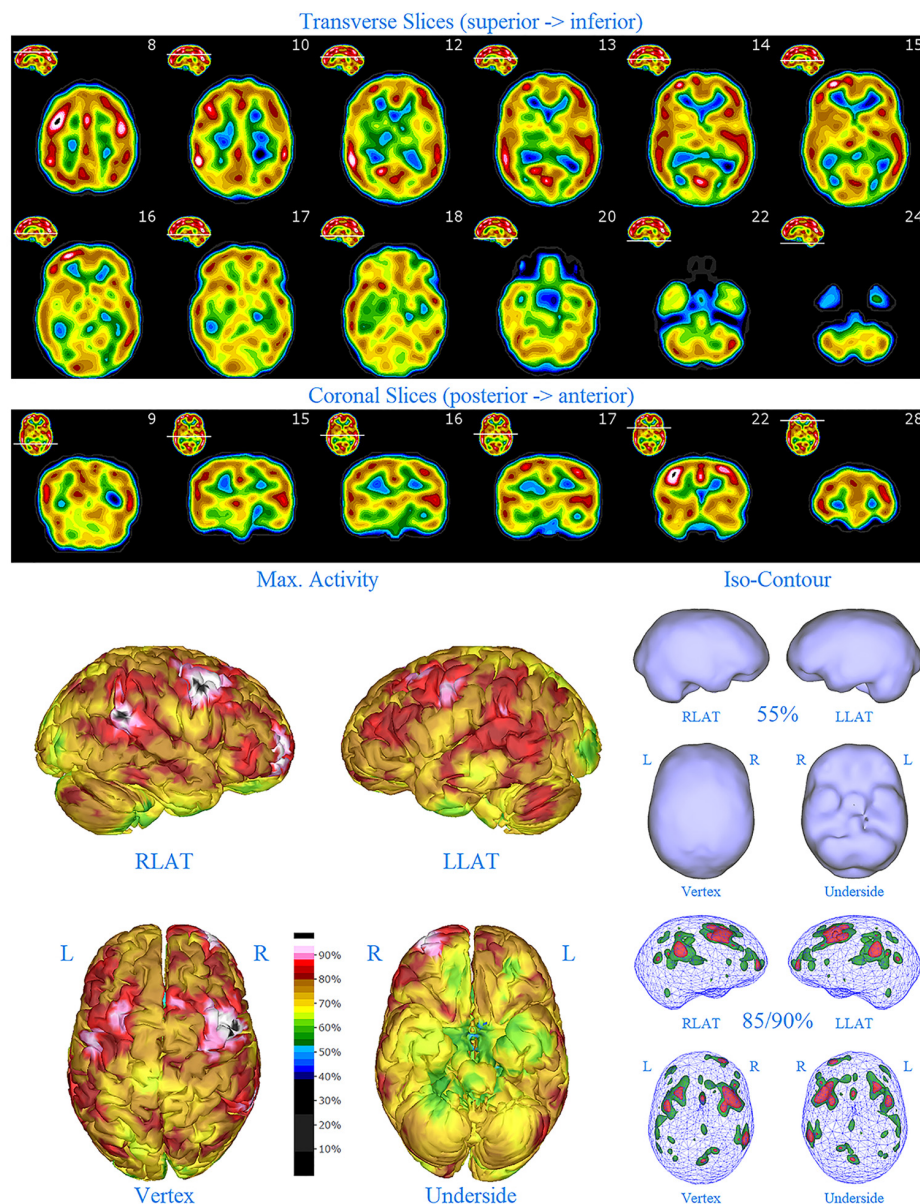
First perfusion SPECT scan of Patient D. Arrangement, color scales, and views are identical to Figure 1. Anatomical structures such as the thalamus are positioned similarly to the scan shown in Figure 2. Labeling was eliminated to avoid obscuring the scan details. Perfusion of the thalamus is increased and asymmetrical. Multiple cortical areas of markedly increased perfusion are evident in the right frontal and right parietal cortices.
